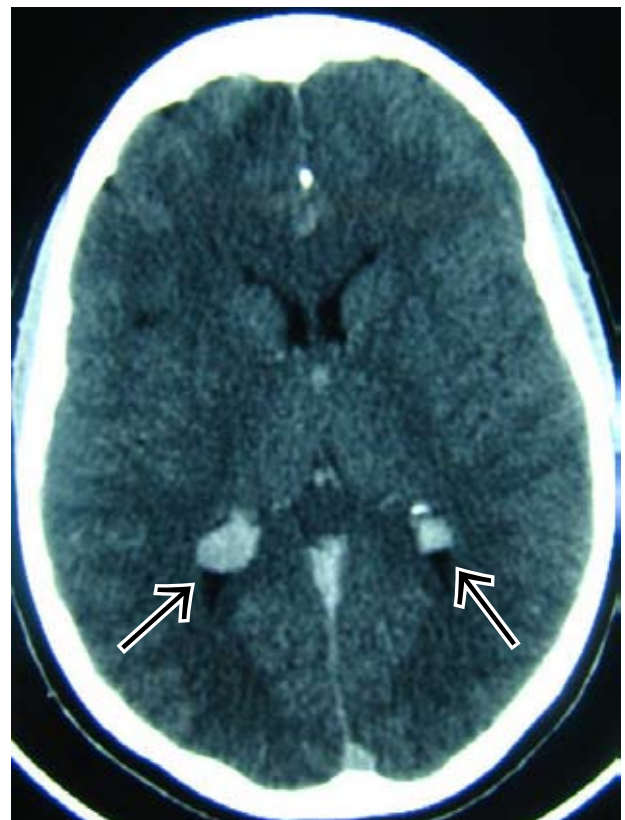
Axial contrast-enhanced CT scans at different levels showing multiple intracranial schwannomas (acoustic), meningiomas, and ependymomas of the lateral ventricles (MISME). Note also in Fig. 20a an abnormally tortuous optic nerve on the right.
